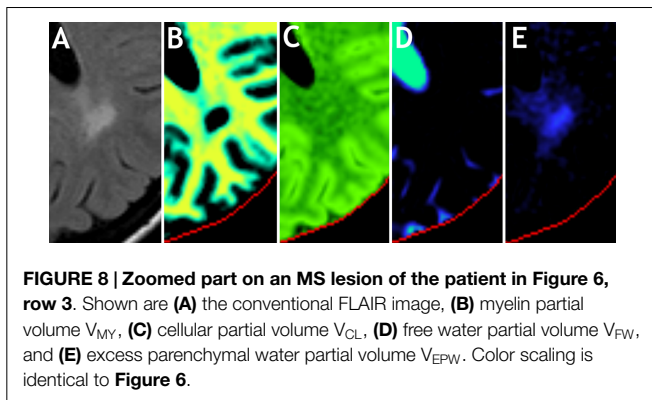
Zoomed part on an MS lesion of the patient in Figure 6, row 3. Shown are (A) the conventional FLAIR image, (B) myelin partial volume V_{MY} , (C) cellular partial volume V_{CL} , (D) free water partial volume V_{FW} , and (E) excess parenchymal water partial volume V_{EPW} . Color scaling is identical to Figure 6.
